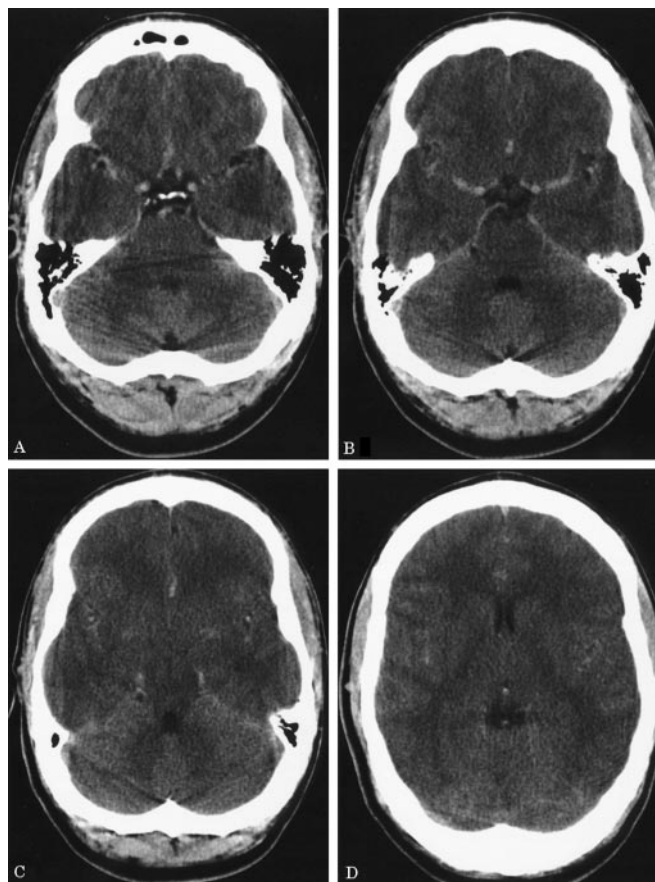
Noncontrast CT scan obtained upon admission shows hyperintensity in the intravascular space and mild loss of sulcal/gyral pattern.
